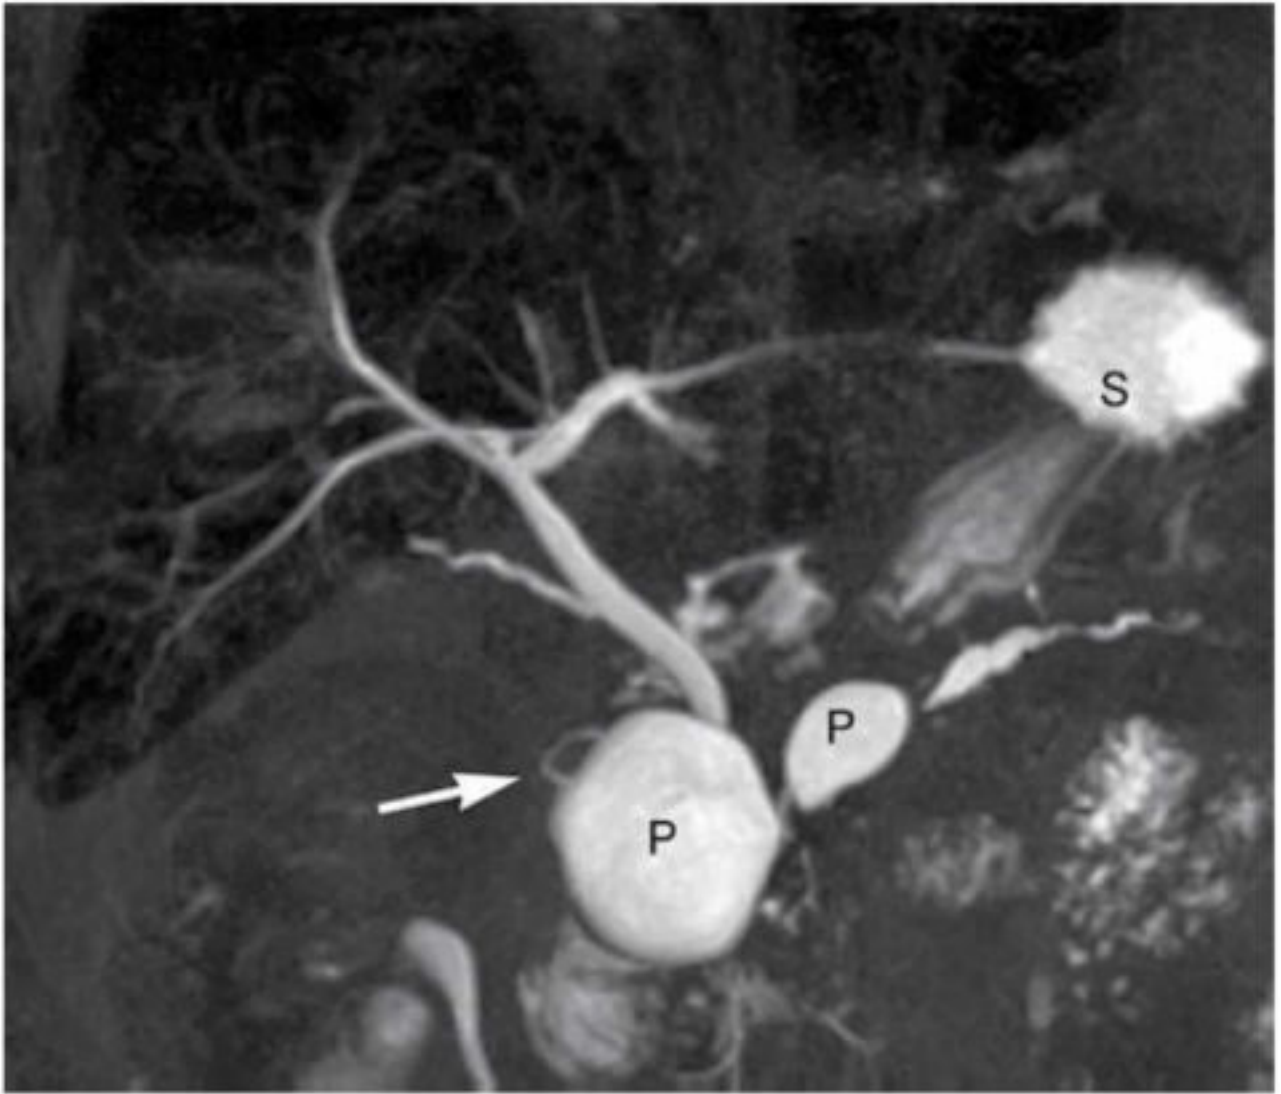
MRI-cholangiography
